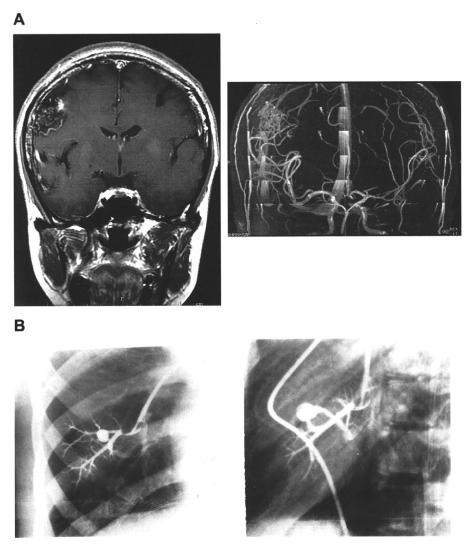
Imaging of the brain and pulmonary AVM in the proband. (A) MRI scan and MR angiogram of the proband. The AVM is located right frontal lobe measured 2.0 × 1.3 cm. (B) Pulmonary angiograms of the proband. The pulmonary AVM is located in the right lower lobe (rtS8b) with 24% of shunt-rate.
